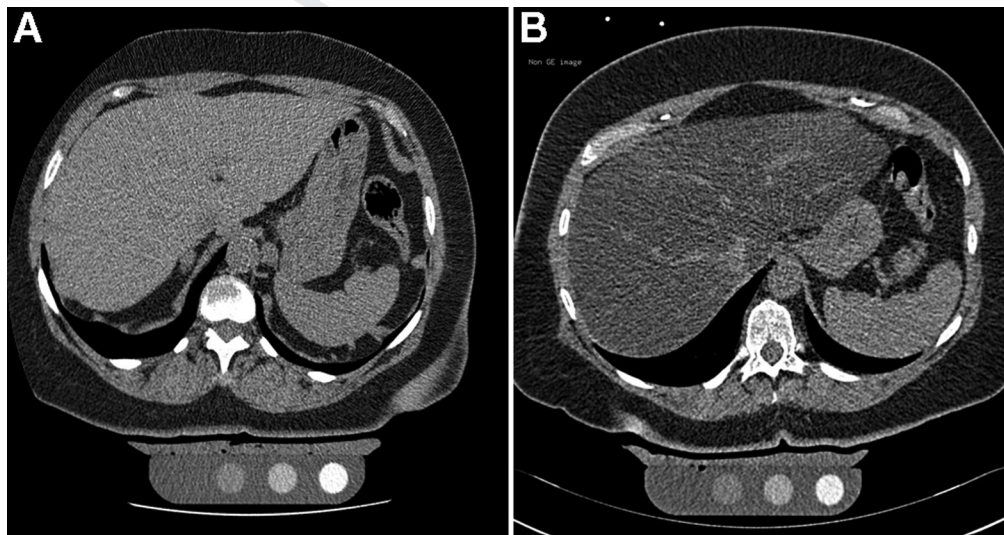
Examples of abdominal CT images showing the liver (L) and spleen (S) from persons with high liver attenuation, ie, low liver fat content (A) and one with low liver attenuation, ie, high liver fat content (B). Liver attenuation in HU was used as a quantitative variable and also to define fatty liver (attenuation <40 HU) in the main analysis. In images where spleen image was available, liver-to-spleen attenuation ratio was calculated, and ratio <1 was defined as fatty liver for Supplementary analysis.
